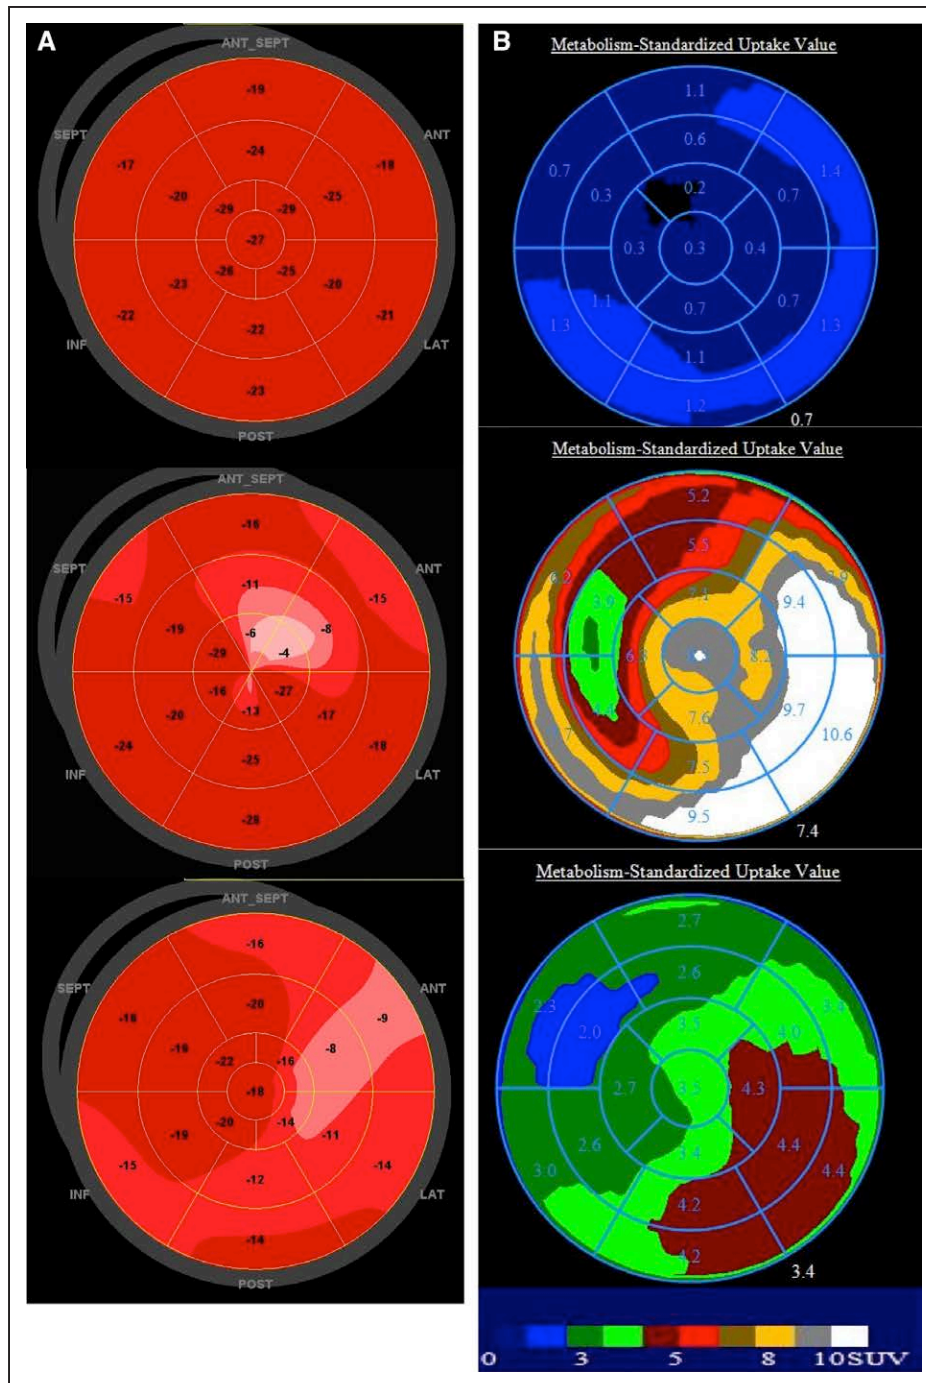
Speckle-tracking echocardiography and ^{18}F -fluorodeoxyglucose (FDG) positron emission tomography in three representative study patients.
